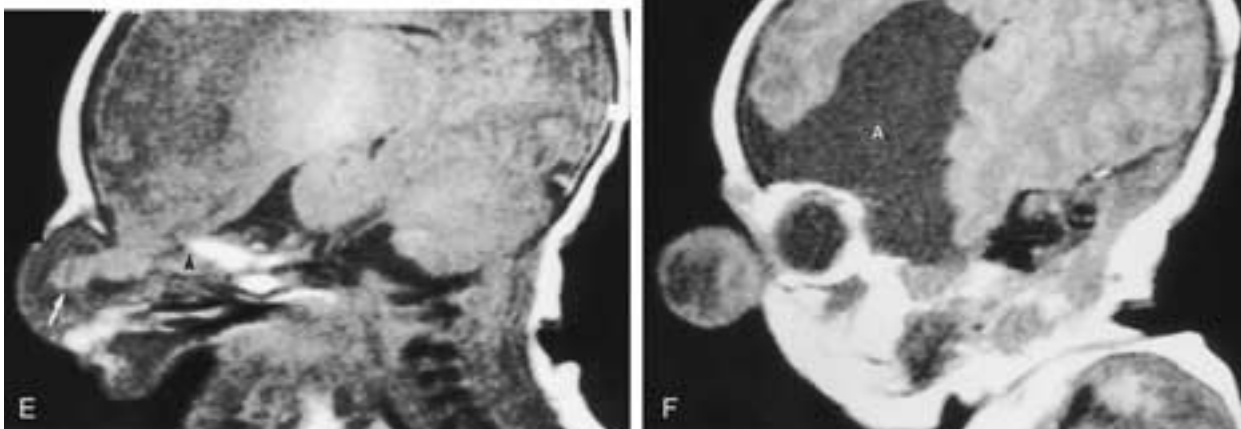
Continued. E and F, Sagittal T1-weighted MR images. The paramedian section (E) demonstrates the intracranial end (black arrowhead) of the osseous canal and direct extension of brain tissue (white arrow) into the medial orbit. The lateral section (F) demonstrates the prominent arachnoid cyst commonly found in these lesions.
